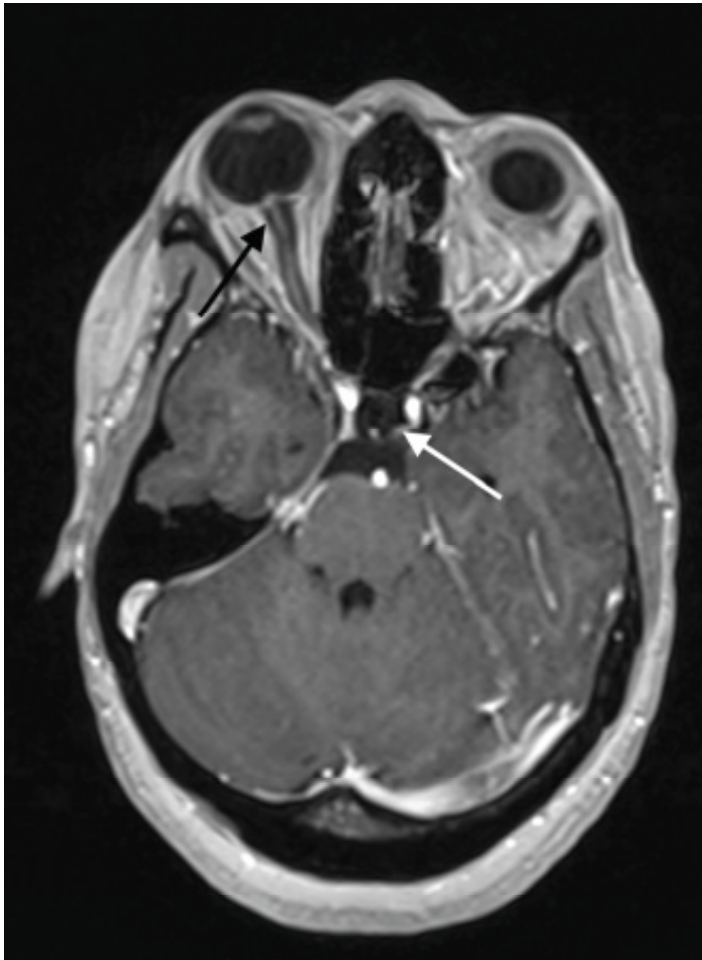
Axial T1 gadolinium enhanced magnetic resonance image of patient's brain. Patient was found to have multiple findings consistent with idiopathic intracranial hypertension including partially empty sella (white arrow) and prominent optic nerve sheath and papilledema (black arrow).
